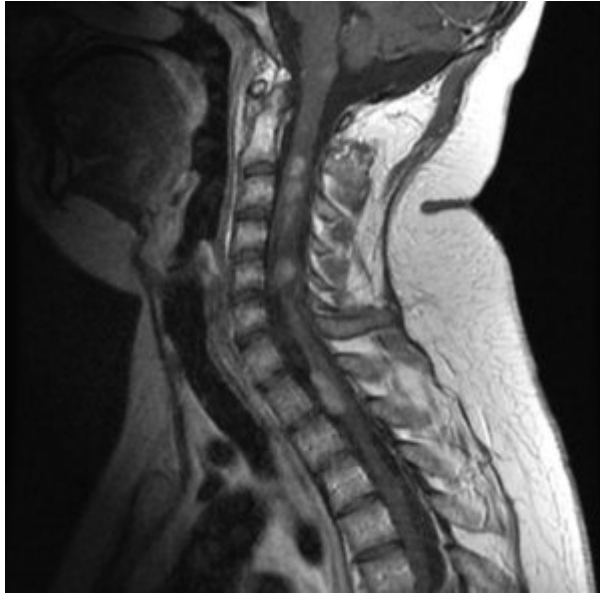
“Multiple ependymomas in a patient with NF2, MRI” by RadsWiki. License: [CC BY-SA 3.0](https://creativecommons.org/licenses/by-sa/3.0/)
